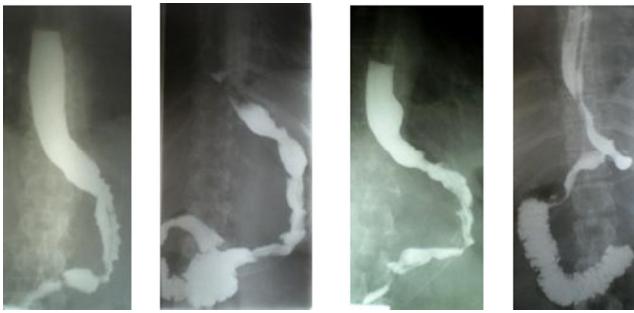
X-rays studies on four different gastric sleeves
